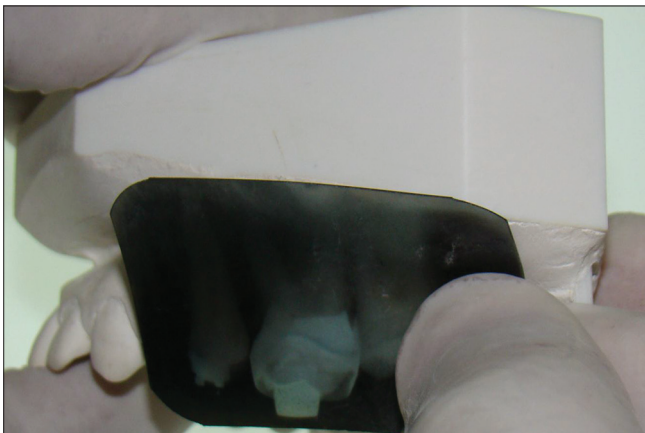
Observation of the extent of tooth roots by overlapping of the periapical radiograph on the working cast
